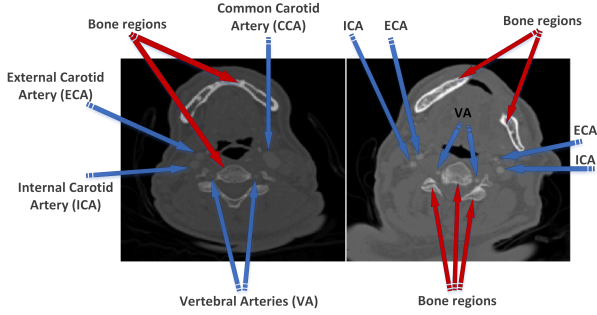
Arteries and bone regions in CTA images
